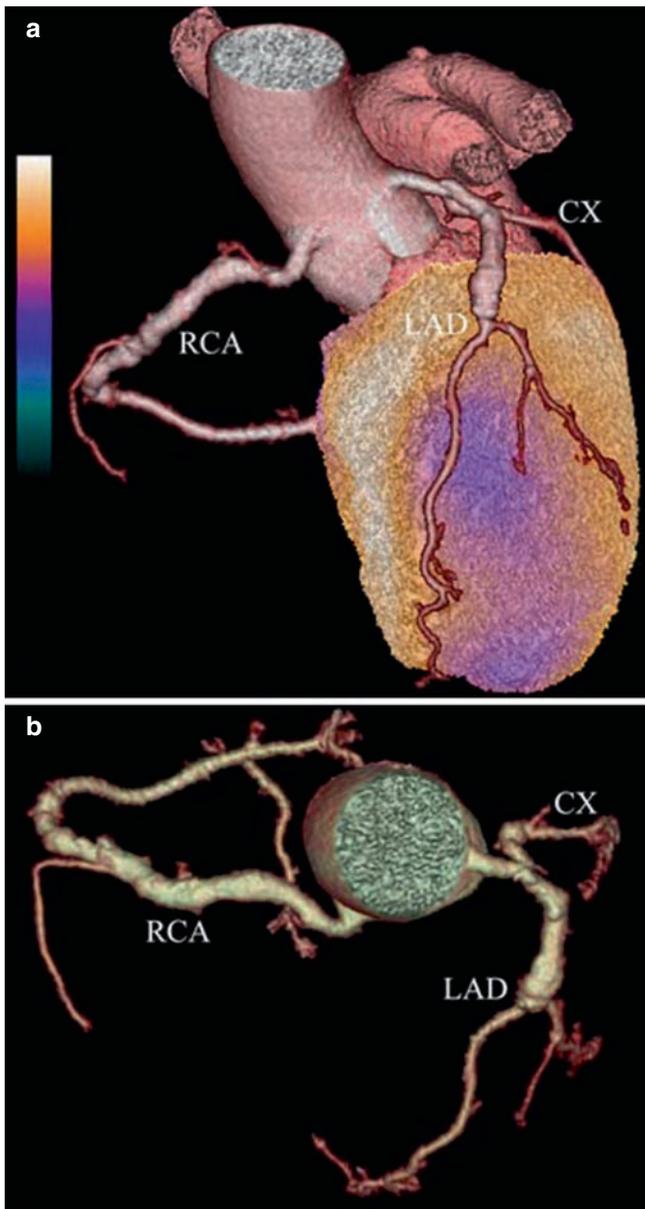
(a) Hybrid images from stress SPECT MPI fused with the CT coronary angiography indicating that the territory subtended by the ectatic left anterior descending (LAD) is ischaemic (blue area). (b) CT coronary angiography shows the extent of the ectatic coronary disease involving the right (RCA) and the circumflex (CX) coronary arteries. With permission from Husmann et al.³³
